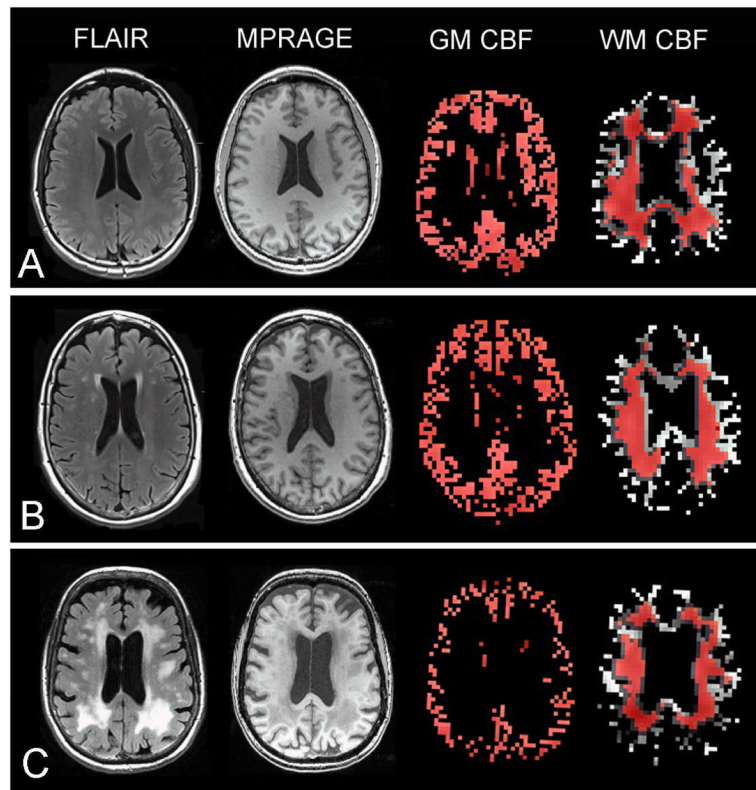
Sample axial FLAIR, MPRAGE, gray matter (GM) CBF map, and white matter (WM) CBF maps in a (A) control, (B) MCI patient, and (C) AD patient. The red regions represent the overlap between the GM and WM masks used to extract CBF within these segments and the GM and WM segmentations derived from anatomical data.
